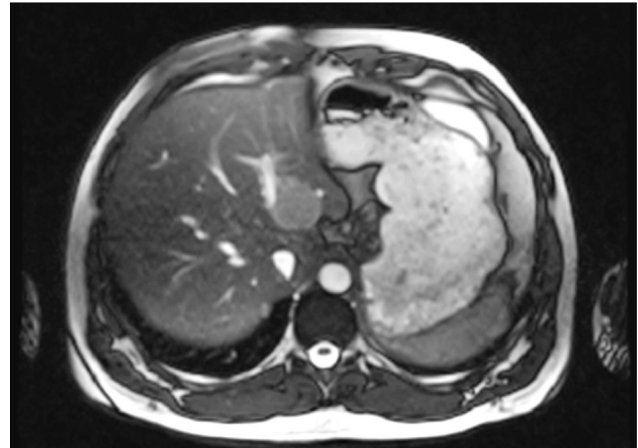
MRI showing a T2 hyperintensity liver tumor mass in the left lobe
